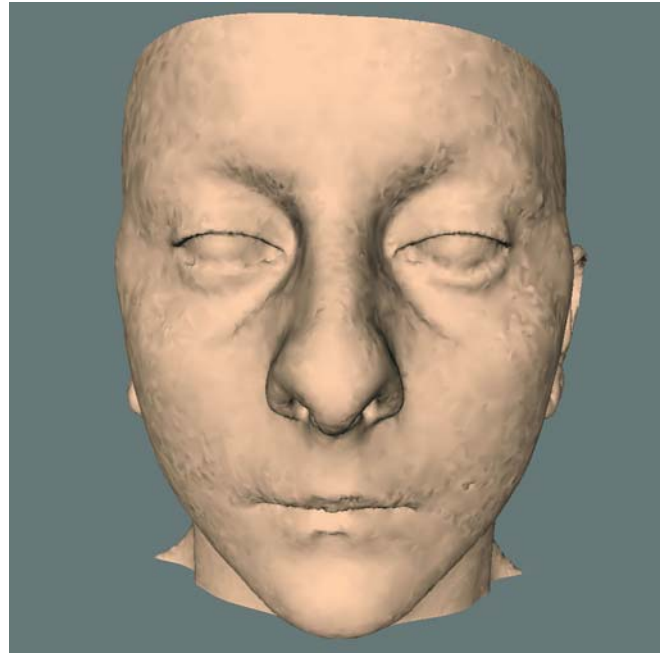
3-D CT soft tissue surface presentation (Maxilim, version 1.3, www.medicim.com) of a patient (patient F.L.)
